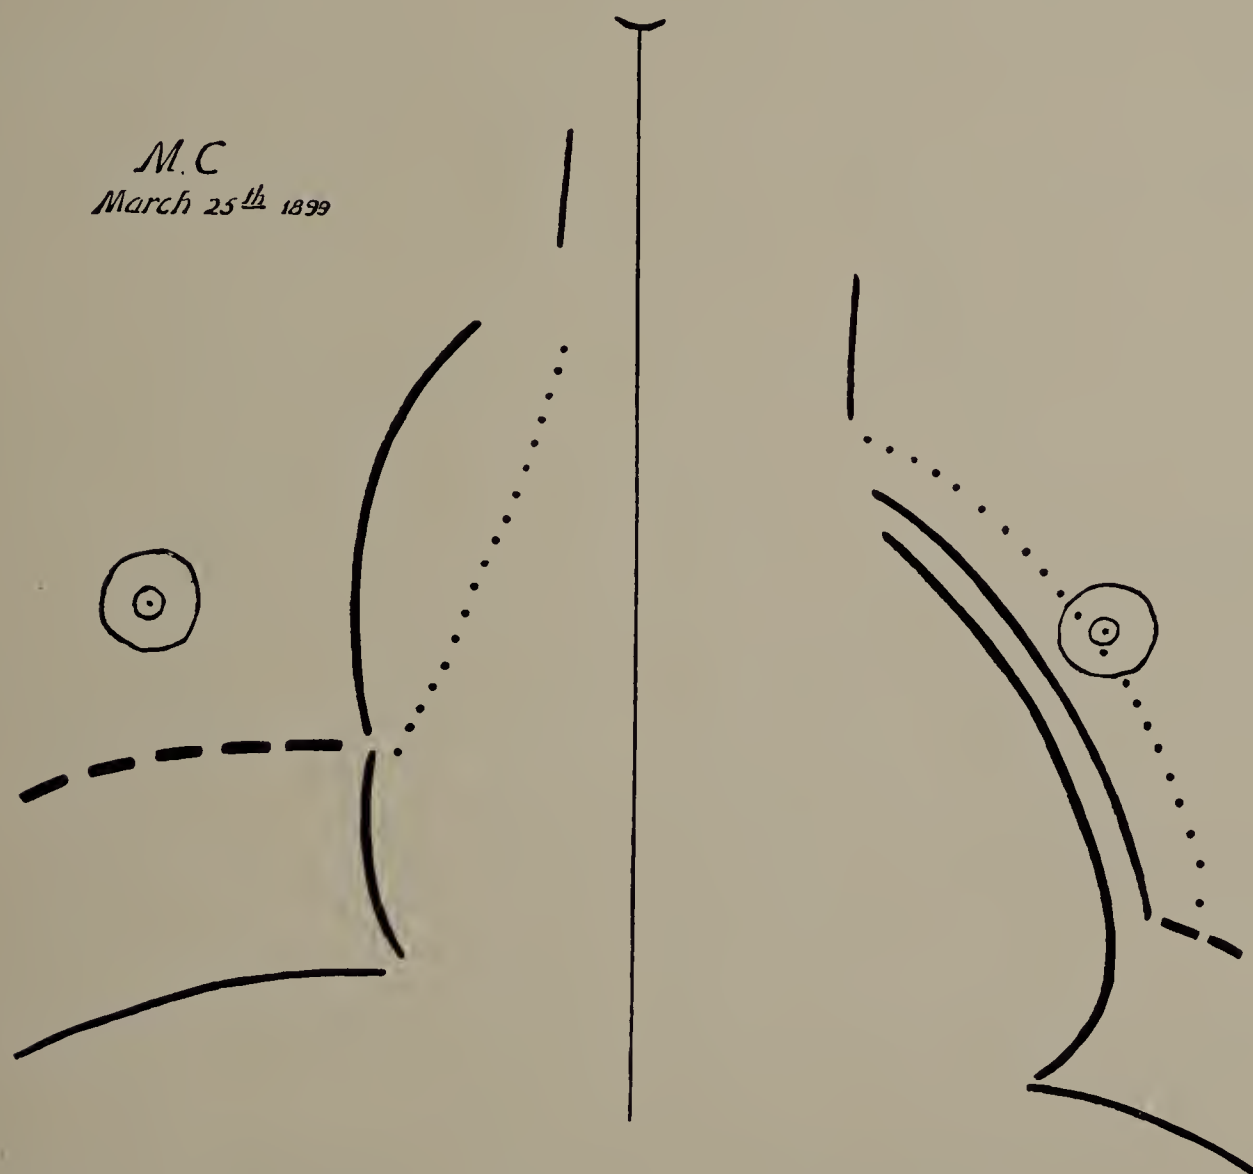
M. C. Second X-ray tracing (one-third life size). The dotted line indicates the cardiac outline as determined by percussion; the full line (except of course the median line and the curve indicating the suprasternal notch) and the broken lines, the outlines of the heart and diaphragm as obtained by the X-rays. The outer full line on the left indicates the position of the heart in expiration; the inner, in full inspiration. The distance between the median line and the left border of the heart as obtained by the X-ray examination is slightly exaggerated, owing to the manner in which the outlines are recorded on the tracing cloth. The error is still greater by percussion.
